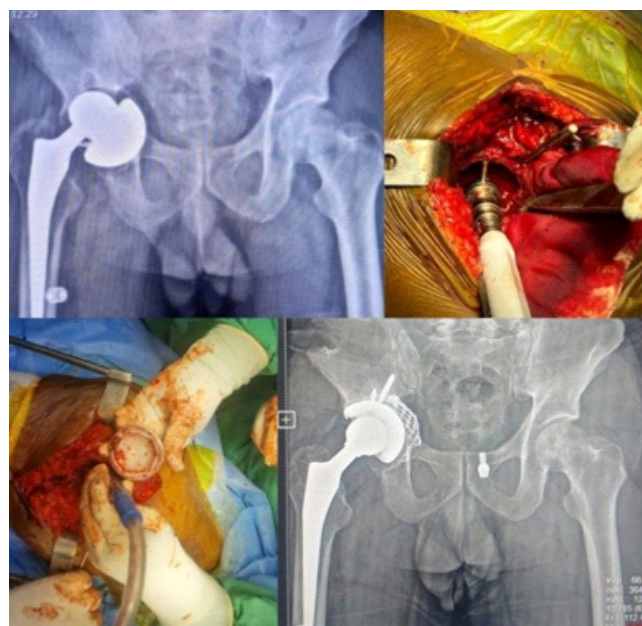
Case 1: Pre-operative, intraoperative photos and post-operative X-rays.
